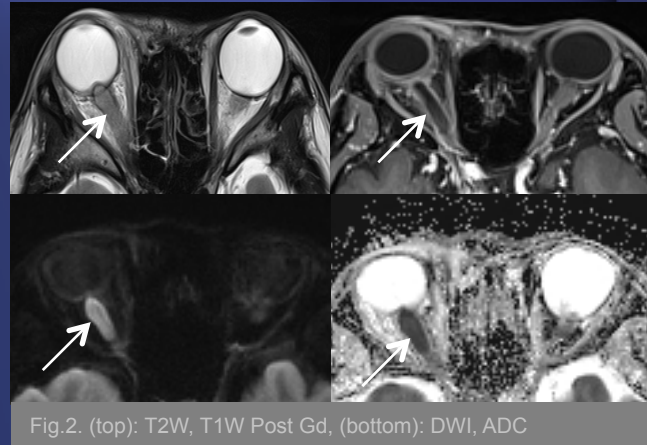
(top): T2W, T1W Post Gd, (bottom): DWI, ADC
